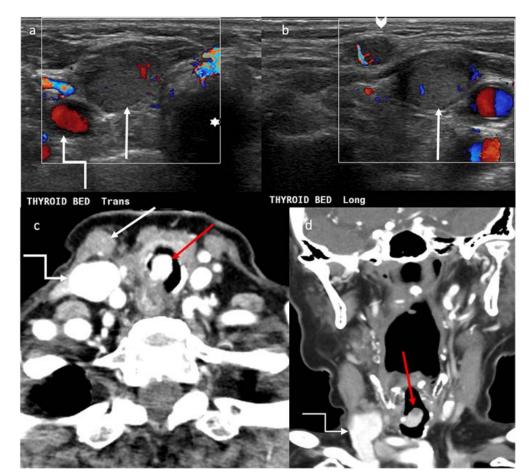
A 92-year-old female presented with stridor after total thyroidectomy. Post thyroidectomy reveals a follicular cell carcinoma. Endoscopy reveals a nodular lesion within the larynx. Transverse ultrasound image (a) shows a large hyperechoic nodular lesion in the right thyroid bed situated between the trachea medially (white star) and the right internal jugular vein laterally (connector elbow arrow). This nodular lesion is suspected of recurrent tumor in the surgical bed. Longitudinal ultrasound image (b) shows an abnormal lymph node with absence of central echogenic hilum (arrowhead) located anterior to the aforementioned recurrent lesion in the thyroid bed (straight arrow). Axial (c) and Coronal (d) contrast-enhanced CT neck reveals nodular lesions in the right thyroid bed (straight arrow) situated anterior to the right IJV (connector elbow arrow) and within the subglottic larynx (red arrow). Subsequent biopsy of the thyroid bed and subglottic nodular lesions reveal (recurrent) follicular cell carcinoma.
